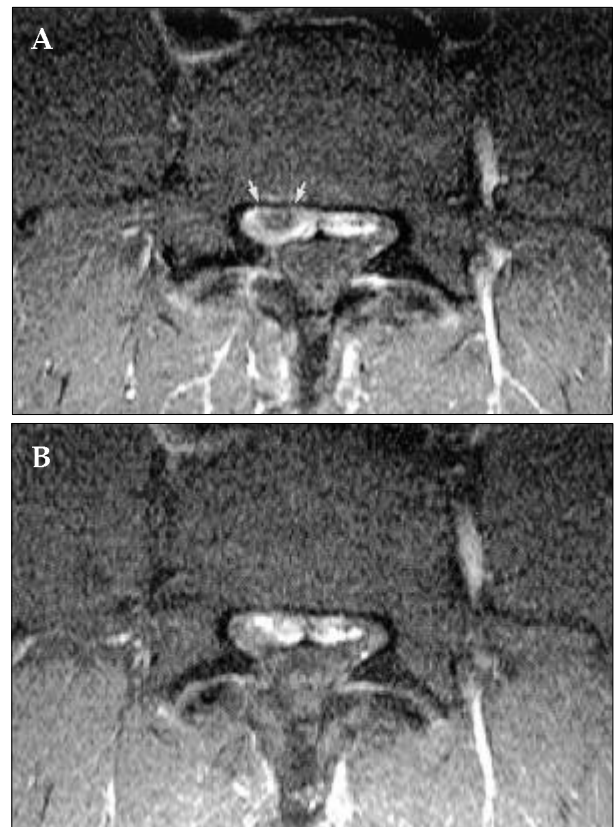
Morphologic changes in a sequestered disc. Postcontrast fat suppressed axial T1-weighted images (583/12) in a 25-year-old man with right-side sciatica. A, Sequestered disc with ring-enhancement was observed in the initial study (arrows). B, Follow-up study showed nearly complete disappearance of the sequestered disc herniation 6 months later. The patient showed no pain or activity limitation.
